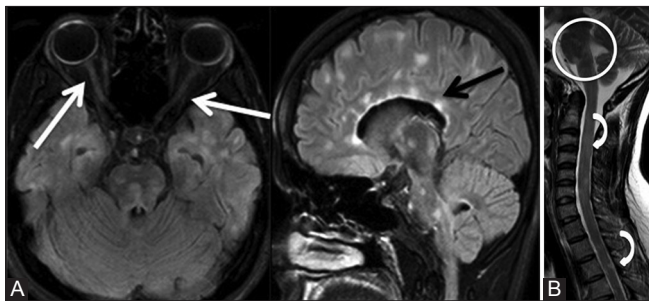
(A and B): Demyelination: Multiple sclerosis. Axial and sagittal FLAIR (A) images of brain in a 26-year-old female show hyperintense signal in bilateral optic nerves (white arrows) and periventricular plaques (black arrow). Sagittal T2W (B) image of posterior fossa and upper spine reveals multiple plaques in brain stem (circle) and lesions in spinal cord (curved arrows)
